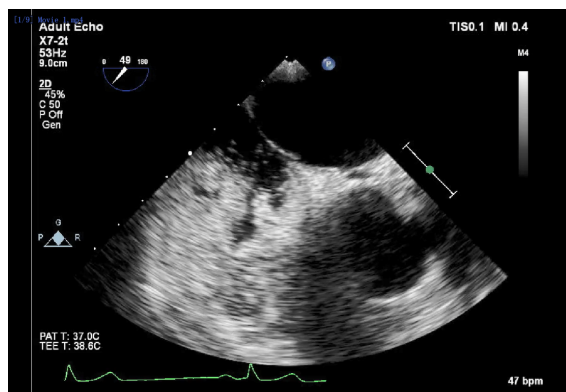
Agitated saline injection for the detection of right-to-left shunts. (A,B) Example of intracardiac right-to-left shunting through a patent Foramen Ovale; transoesophageal echocardiography in mid-oesophageal position at 45°. The right atrium (RA), left atrium (LA) and interatrial septum at the level of the fossa ovalis are seen (arrow). After the infusion of agitated saline in a peripheral vein, a thick cloud of bubbles is seen passing through the patent *foramen ovale* (PFO) (arrow). (C,D) Right-to-left shunting through an intrapulmonary shunt, detected with transthoracic echocardiography, apical 4-chambers view. All four cavities are visualised. After the infusion of agitated saline in a peripheral vein, the right cavities are completely opacified. Seven heart cycles after the appearance of contrast in the right heart, a thick cloud of bubbles is seen in the LA (arrow), coming from the left lower pulmonary vein (LLPV). Source: personal collection.
